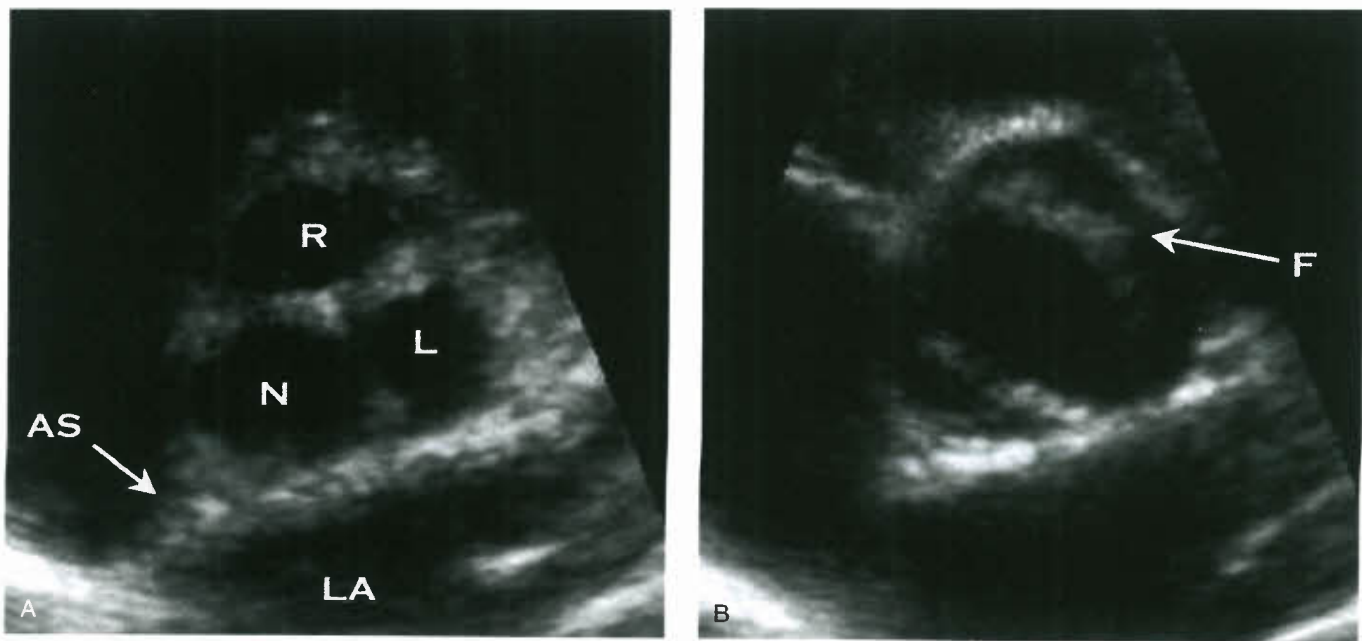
Echocardiographic parasternal short-axis views of a bicuspid aortic valve. A: Diastole, with cusps closed and appearance of three separate cusps. B: Valve opening during systole, with fusion of the right and left coronary cusps (F) evident. R, right coronary cusp; L, left coronary cusp; N, noncoronary cusp; AS, atrial septum; LA, left atrium.
